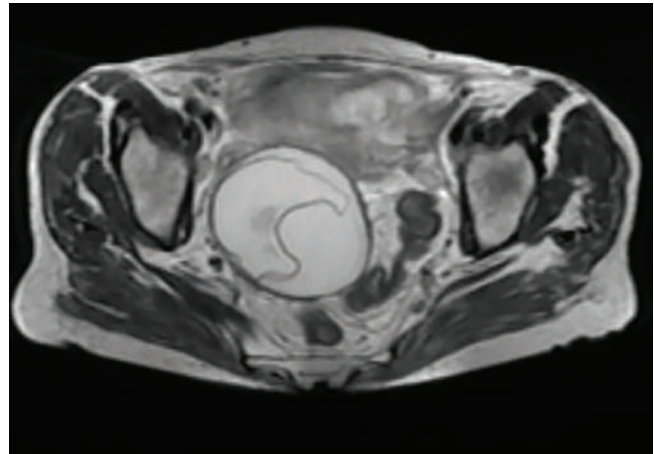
MRI image of hydatid cyst in the pouch of Douglas.
